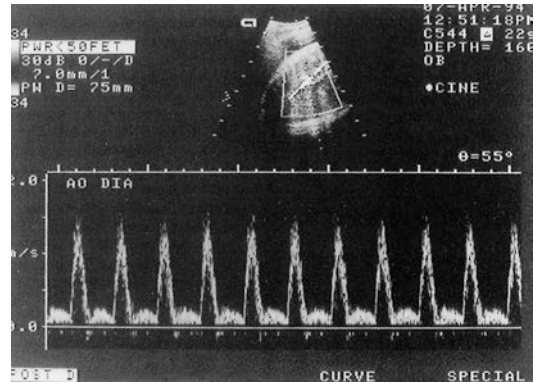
Doppler shift spectrum recorded from the thoracic descending aorta of a healthy fetus at 28 weeks' gestation
